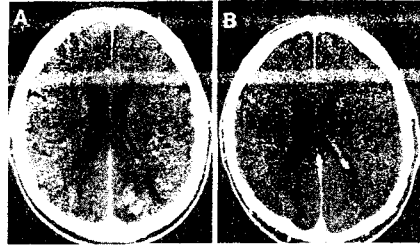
Contrast enhanced CT scans at 2 weeks (A) and 6 months (B) show partial and then complete resolution of the left occipital mass.
